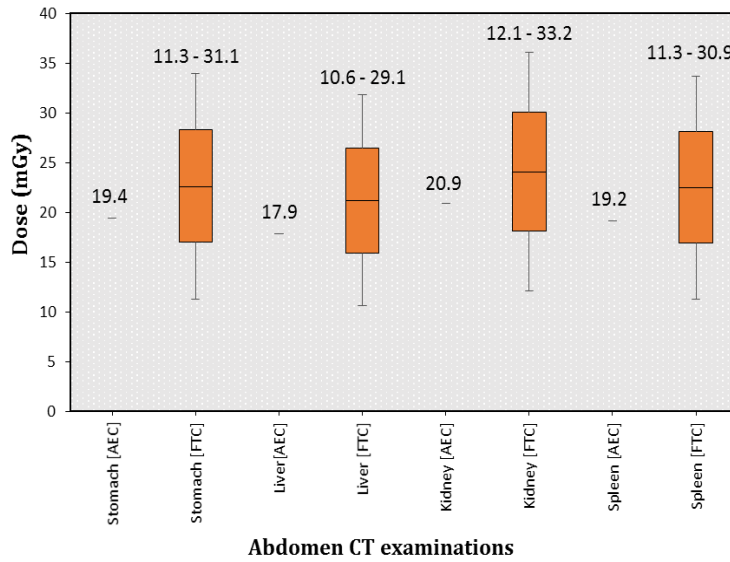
Organ doses for Abdomen computed tomography examinations
